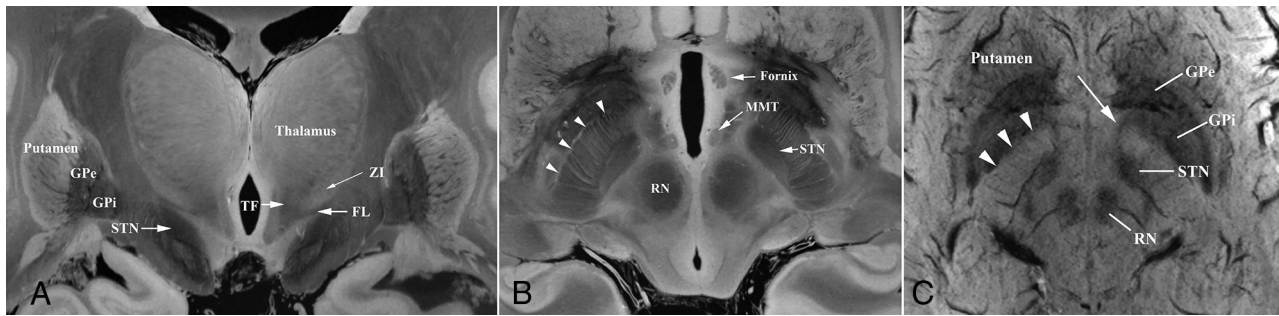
Coronal (A) and axial 7T MR imaging (B) showing the relationship of structures of the basal ganglia and subthalamic area. The ZI is bordered inferiorly by the FL and superiorly by the TF as it inserts into the thalamus. The Edinger comb system can be seen as *dark lines* traversing the internal capsule perpendicularly (*arrowheads*) composed of the pallidofugal tracts, fasciculus subthalamicus, and FL. Axial susceptibility-weighted MR imaging (C) shows similar anatomy including the Edinger comb (*arrowheads*) and the ansa subthalamica (*arrow*). RN indicates red nucleus.
